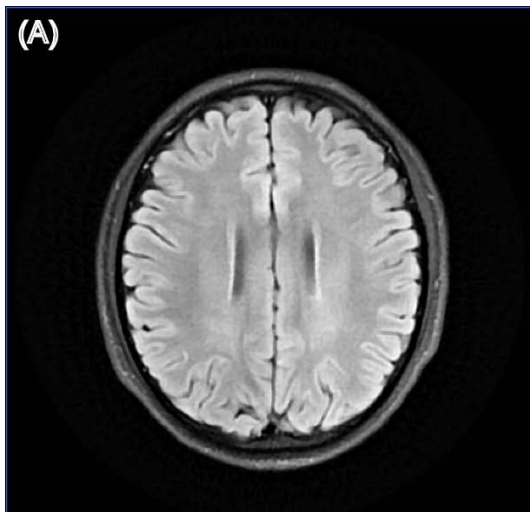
Structural brain MRI images of patient 30. (A) T2-weighted fluid-attenuated inversion recovery (T2-FLAIR) image; (B) Gadolinium-enhanced T1-weighted (Gd-T1w) image.
